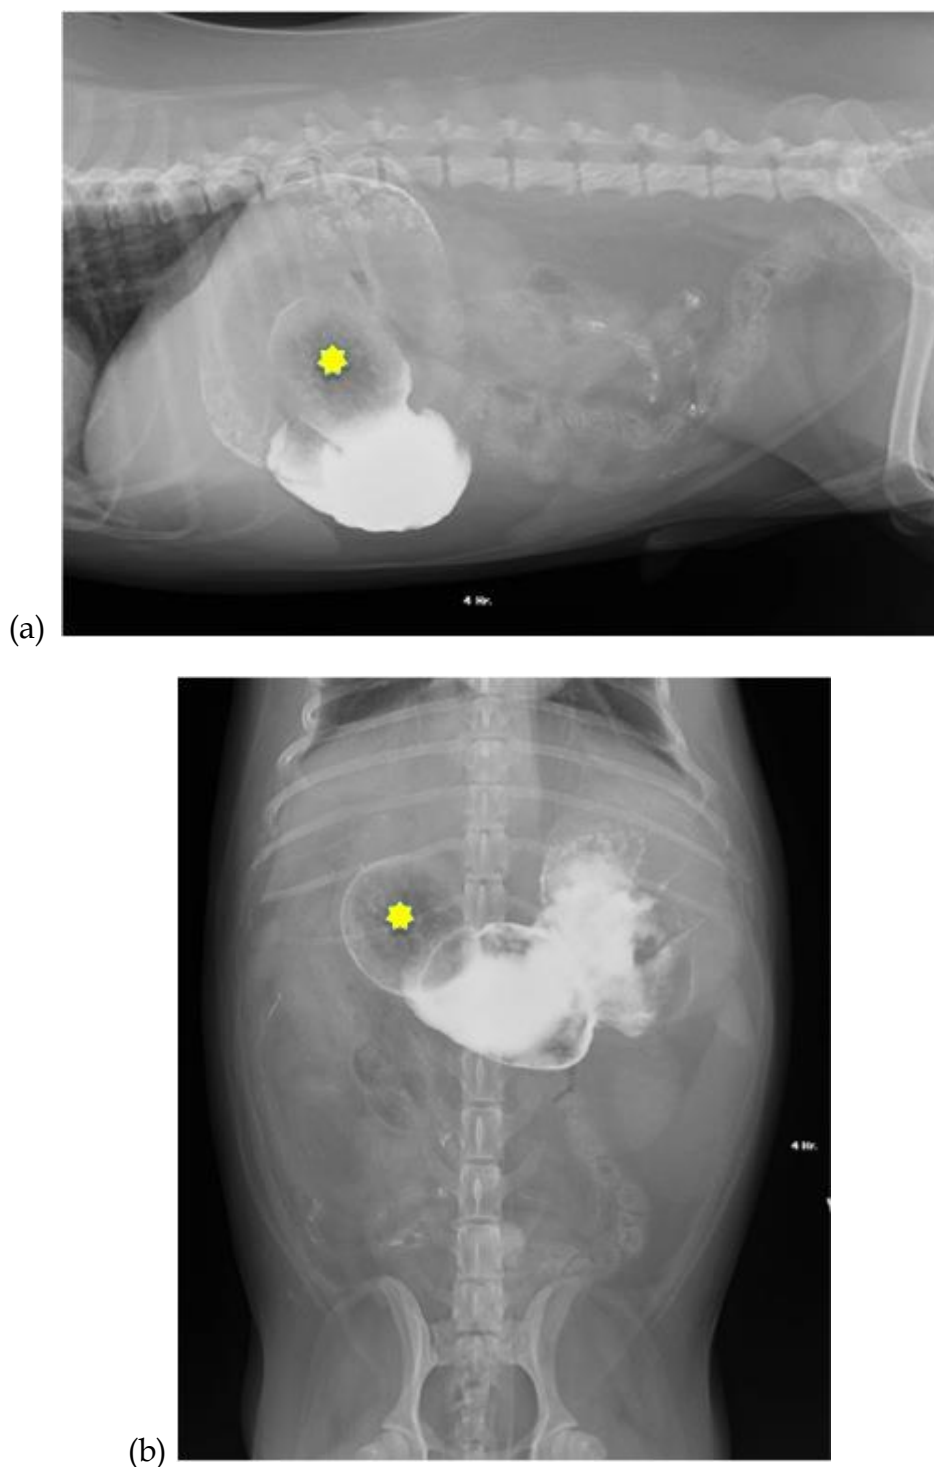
Upper gastrointestinal study with barium swollen on both of right lateral (a) and ventrodorsal (b) radiographs at 240 minutes showed that all barium content was retained in gastric lumen without any evidences of barium in small bowel. Besides, the pyloric area was radiolucent in both radiographic views (asterisk). Therefore, radiolucent foreign body was suggested.
